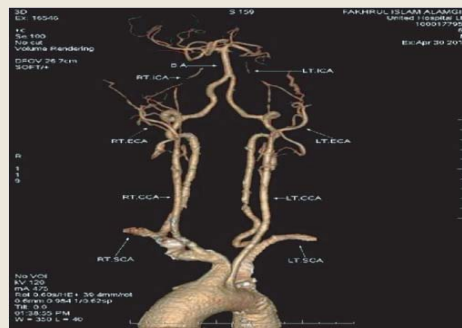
CT Angiogram of neck vessels shows Bilateral Hypoplastic Internal Carotid Arteries.
